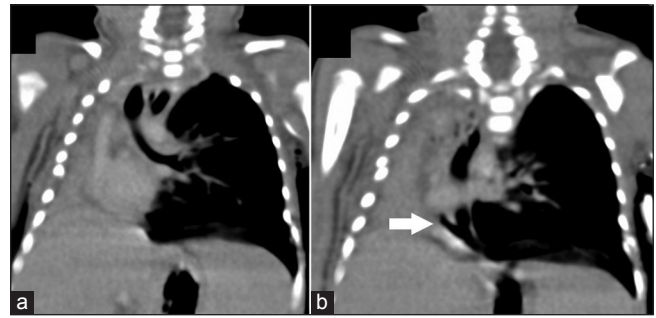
Coronal images of computed tomography scan demonstrating (a) the trachea and left main stem bronchus with absent right main stem bronchus; (b) right sided communication from lower esophagus to the right lung (arrow-communication)
